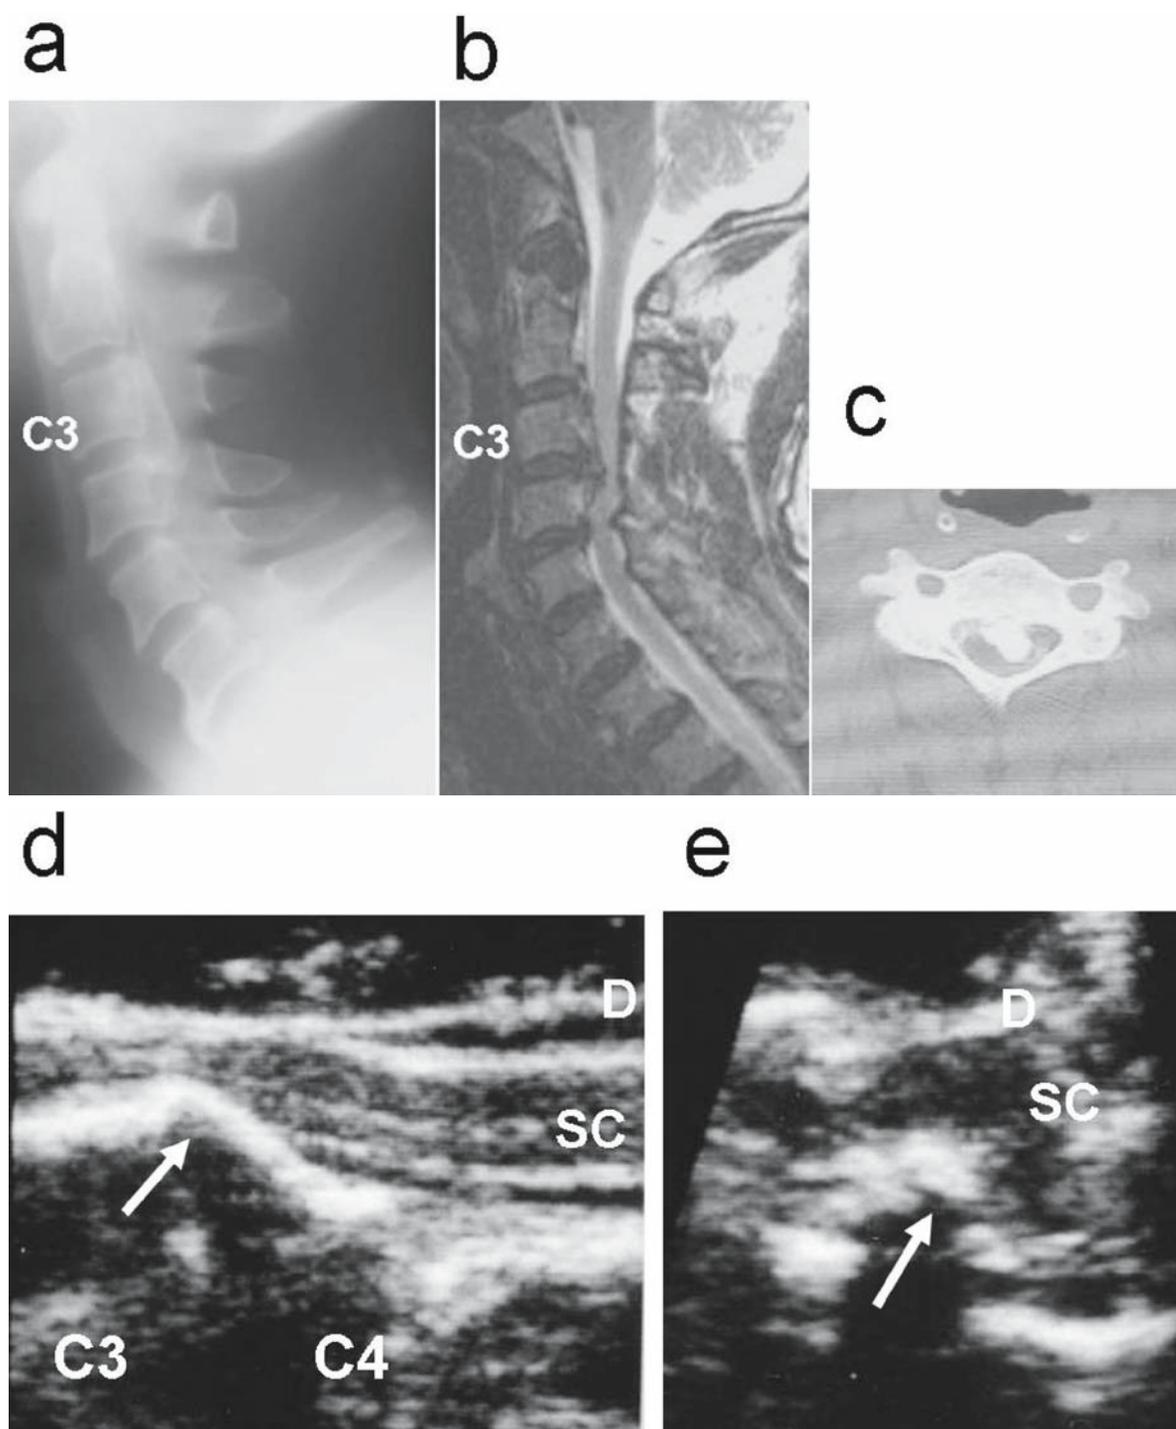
A 56-year-old man with cervical OPLL. a Preoperative tomogram. Continuous-type OPLL was evident from C2 to C5. b MRI. Severe spinal compression by OPLL was observed at C3–C4 and C4–C5 on a T2-weighted sagittal image. c Preoperative CT myelogram at the C3 level. d Long-axis image of the spinal cord during intraoperative ultrasonography. Although the spinal cord (SC) was sufficiently decompressed
